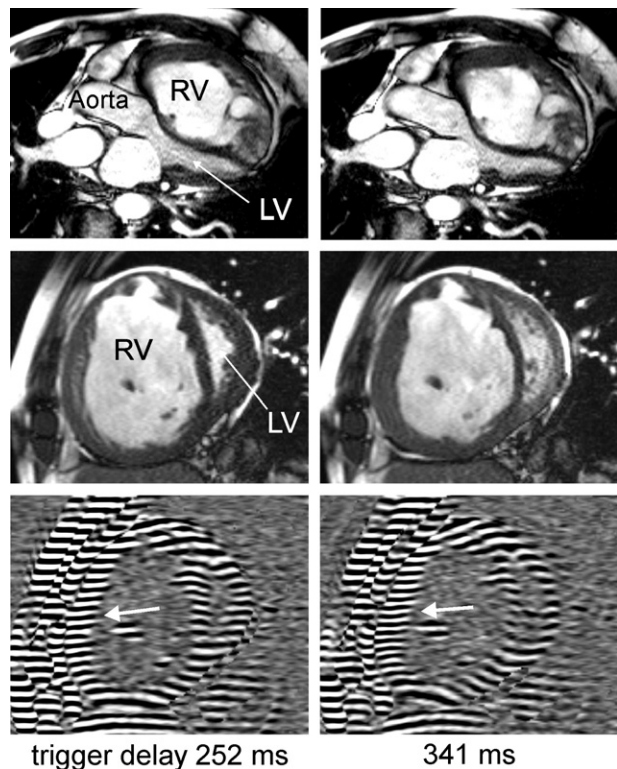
MRI Cine and Tagged Images
